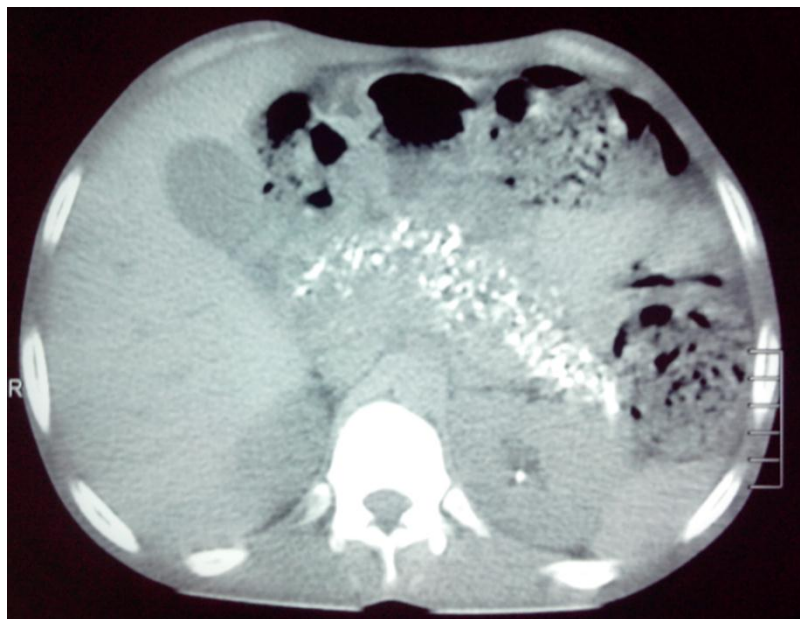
Plain CT showing calcification
